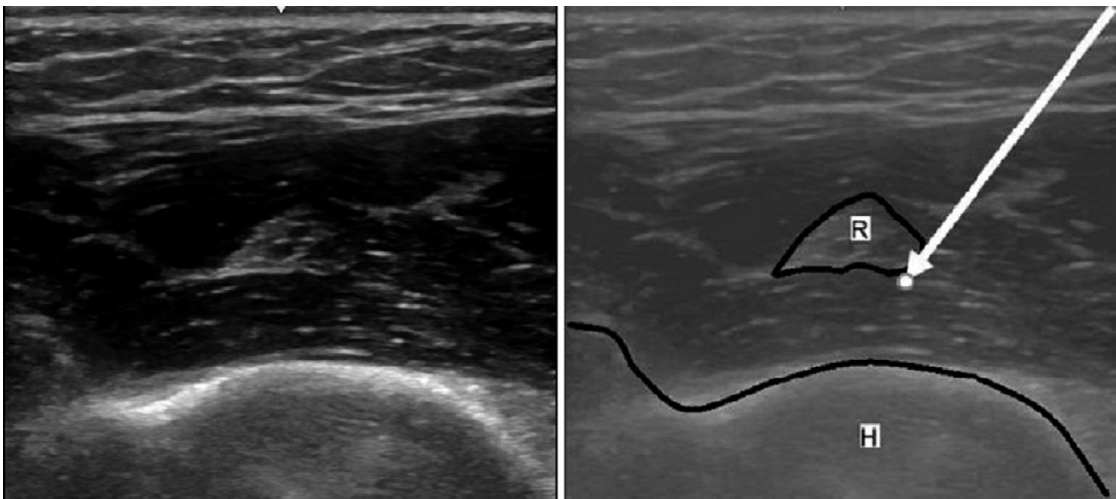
Ultrasound appearance of the radial nerve (R) and humerus (H) at the elbow.
